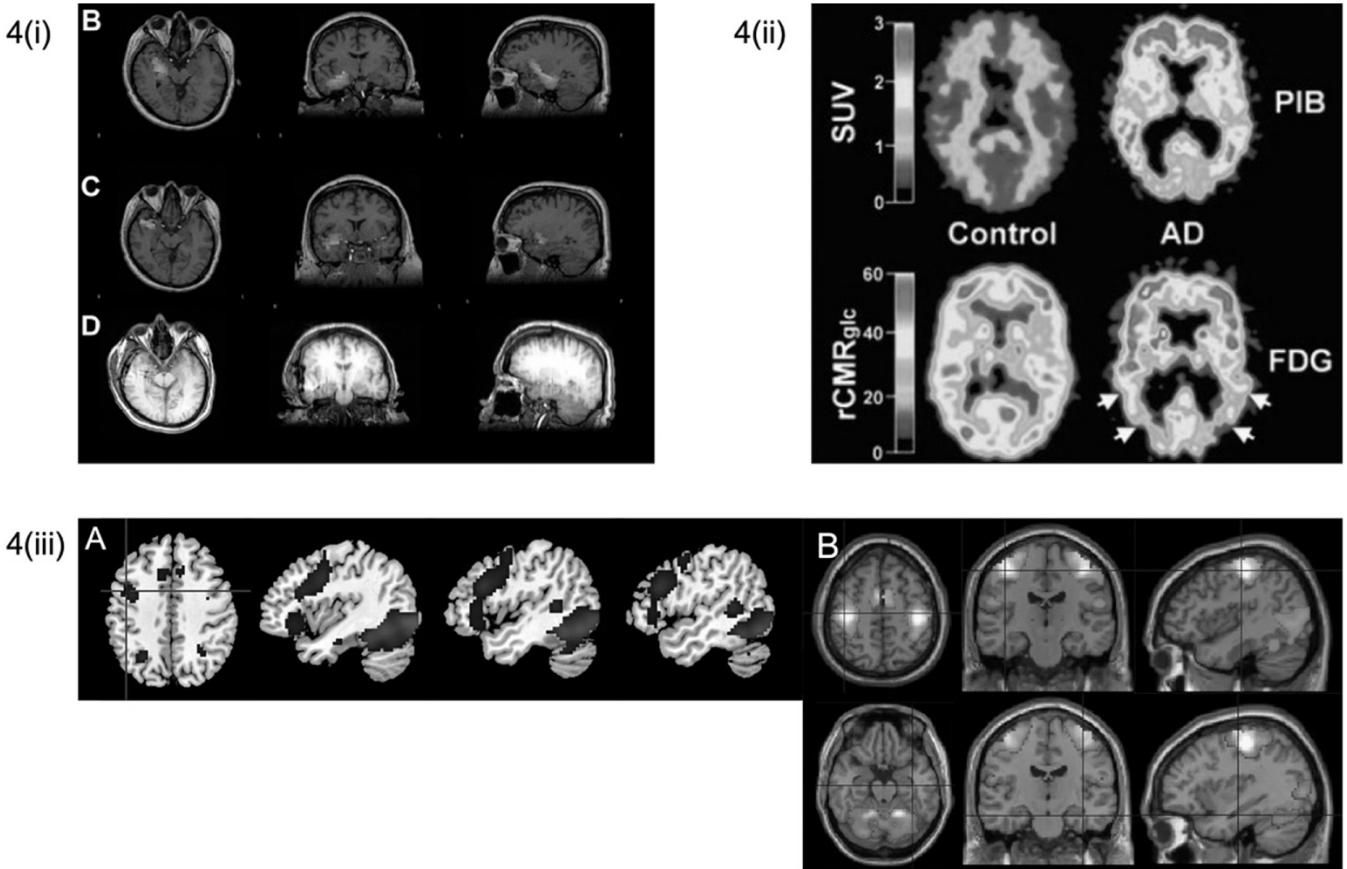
Functional neuroimaging brain maps. (i) Activation maps constructed from magnetoencephalography (MEG) sensor data during a seizure. (B) The synthetic aperture magnetometry (SAM) (g2) statistical parametric maps indicated a right hippocampal focus as well as (C) a focus in the amygdala. (D) A computerized tomography (CT) scan reveals the placement of the hippocampal and amygdala depth electrodes, as well as the location of the hippocampal focus (cross) as identified by SAM(g2). (Reproduced with permission from Stapleton-Kotloski et al (2018) (CC-BY 4.0).) (ii) PIB standardized uptake value (SUV) images of PIB retention in a 79-year-old AD patient (right) and a 67-year-old HC (left). The high PIB retention of the AD patient is seen in the frontal and temporo-parietal cortices (top right). A typical pattern of ¹⁸FDG hypometabolism of AD patient is shown in the temporoparietal cortex (arrows; bottom right) along with preserved metabolic rate in the frontal cortex. (Reproduced with the permission from Klunk et al (2004); Copyright 2004 Wiley and Sons. PIB, Pittsburgh Compound-B; AD, Alzheimer's disease; HC, healthy control.) (iii) (A) Brain activations for Chinese-English bilinguals (N=32) reading English real words, showing activity in the left inferior frontal areas, superior temporal gyrus, middle temporal gyrus and ventral occipito-temporal areas. (B) Brain activations for young healthy adults (N=25) performing hand gripping, activating bilateral motor cortex and cerebellum. (Courtesy of SH Annabel Chen, Clinical Brain Lab, Nanyang Technological University, Singapore.)
